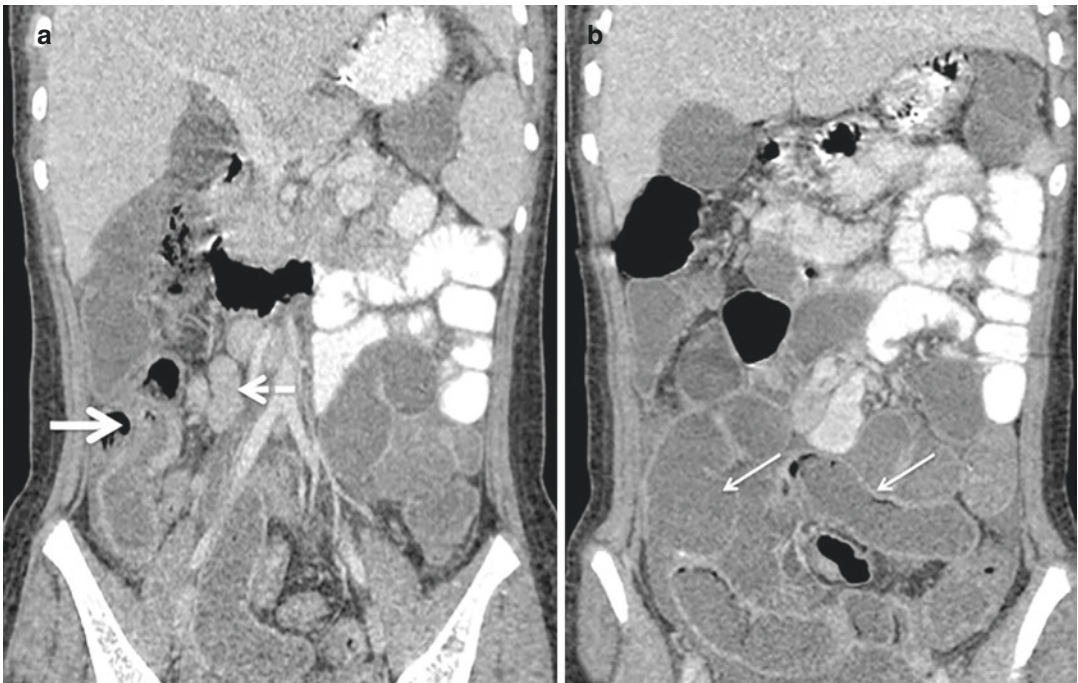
13-year-old girl who presented with abdominal distension, pain, and constipation. (a and b) Coronal contrast-enhanced CT images show a long segment of mural thickening involving the distal ileal loop, ileocecal
